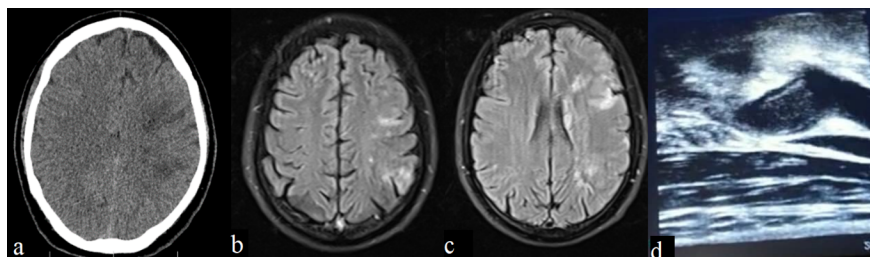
a. CT. Scan, Hypodensity in MCA territory. b & c. MRI, FLAIR, hyperintense lesion in MCA territory. c. Carotid Doppler ultrasonography, acute left ICA complete occlusion.
